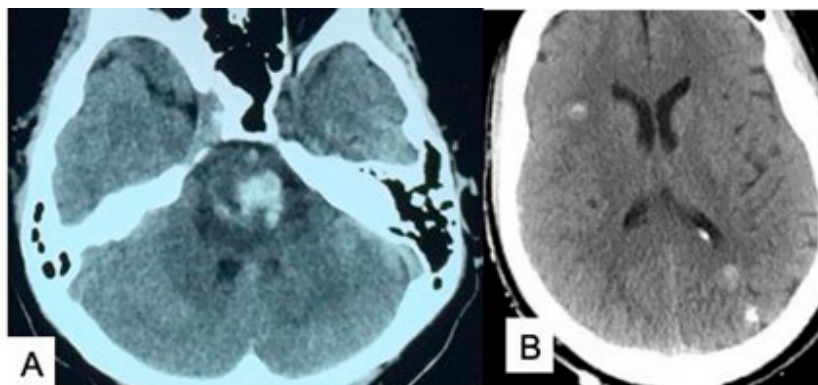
(A) CT scan showing bleeding in the pontine cavernoma. (B) CT scan showing multiple cavernoma. Source: Figure by authors.
